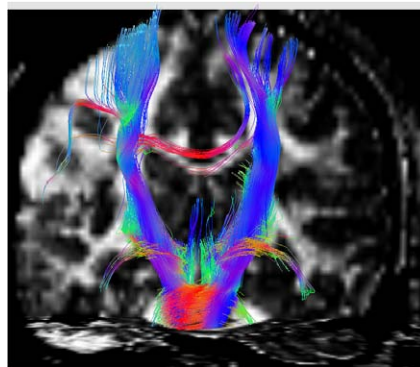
Tractography obtained by using a DT-MRI acquired in the Instituto de Neurocirugía Asenjo (INCA, Santiago, Chile). The position of a set of fiber tracts can be seen from the brainstem to the cortex of both hemispheres. A set of fibers that pass from one hemisphere to the other through the corpus callosum is also shown. Colors represent the tract orientation: blue for axial orientation; green for coronal orientation; red for sagittal orientation.
